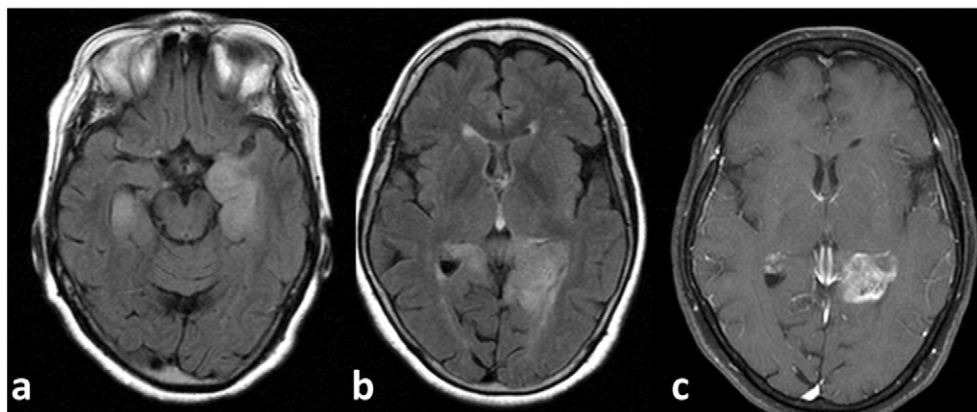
MRI FLAIR image on admission showing high-intensity lesion in bilateral hippocampus (A) and around left corpus callosum (B). Contrast-enhanced T1WI showing heterogeneous enhancement around the left retrocommissural hippocampus (C).
